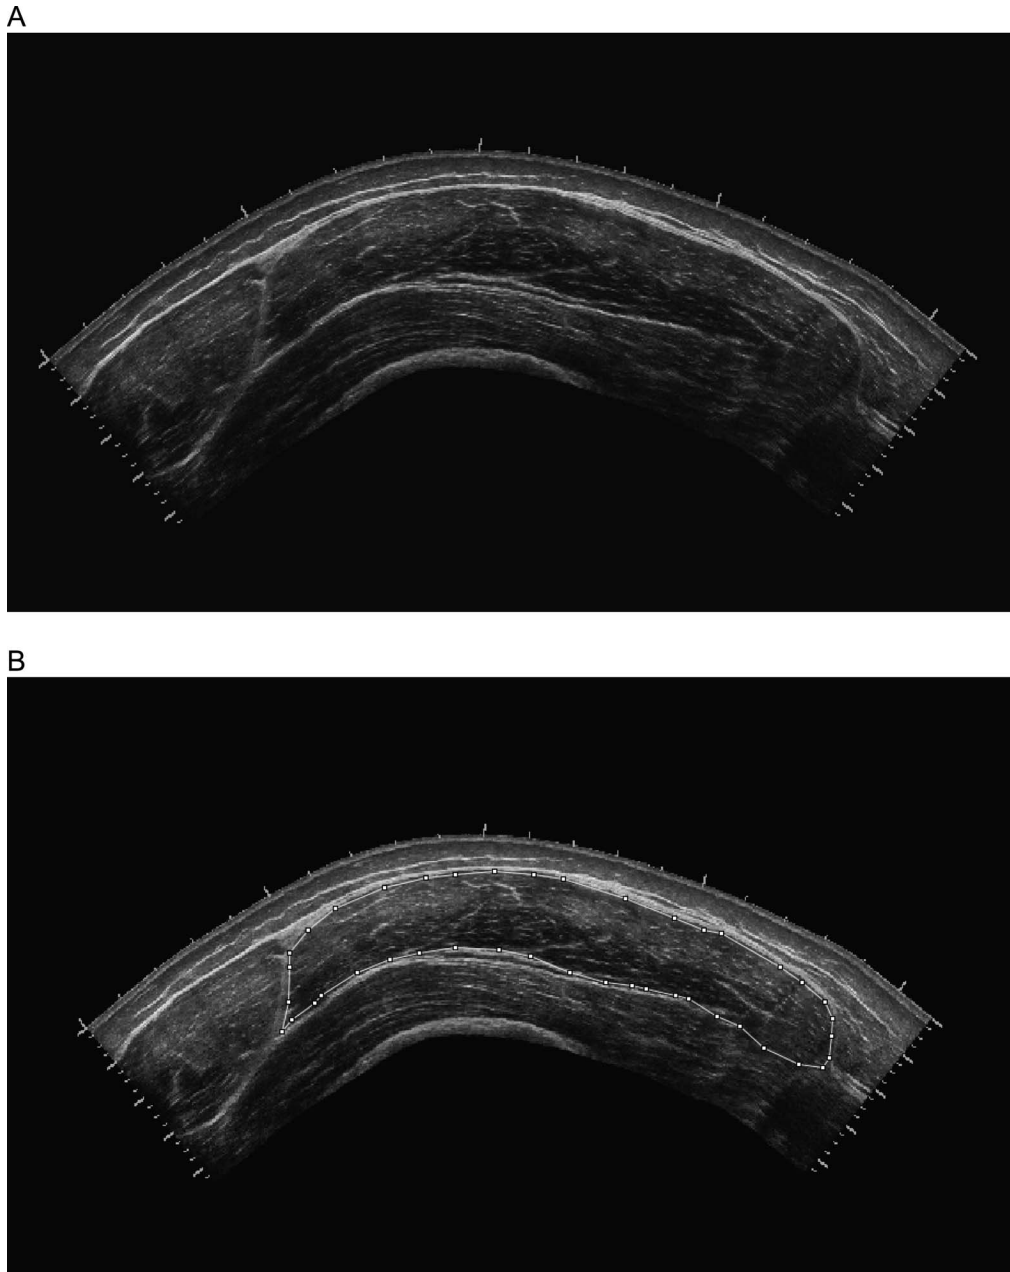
A, Panoramic ultrasonographic scan of the vastus lateralis. B, Analyzing a panoramic scan of the vastus lateralis with Image-J software (National Institutes of Health, Bethesda, MD) to determine muscle cross-sectional area and echo intensity.
